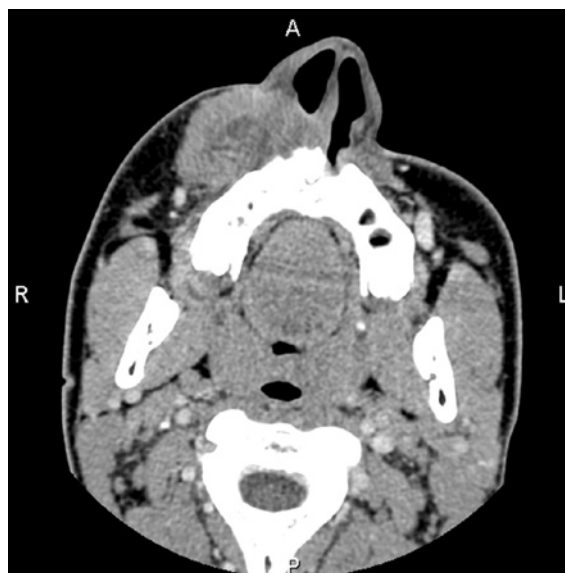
CT scan of patient's head, tumor located on the right side
